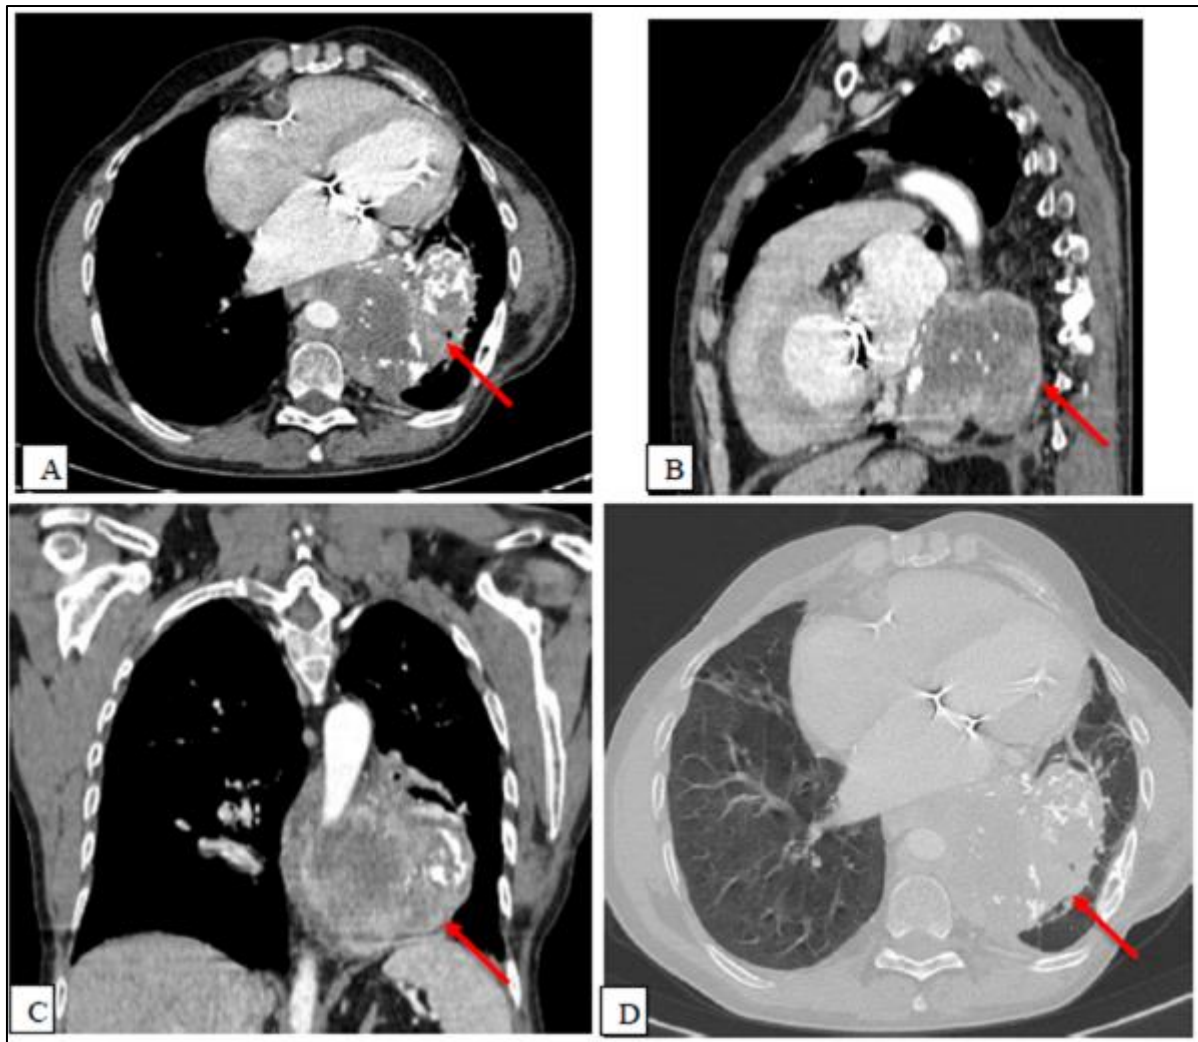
Baseline contrast-enhanced thoracic CT. Axial (A), sagittal (B), and coronal (C) mediastinal window images, along with an axial lung window image (D), demonstrate a large left lower lobe mediastino-pulmonary mass (red arrow). The lesion is ovoid with irregular margins, shows heterogeneous contrast enhancement, and contains internal calcifications. It measures approximately 99 × 95 mm in axial dimensions.
